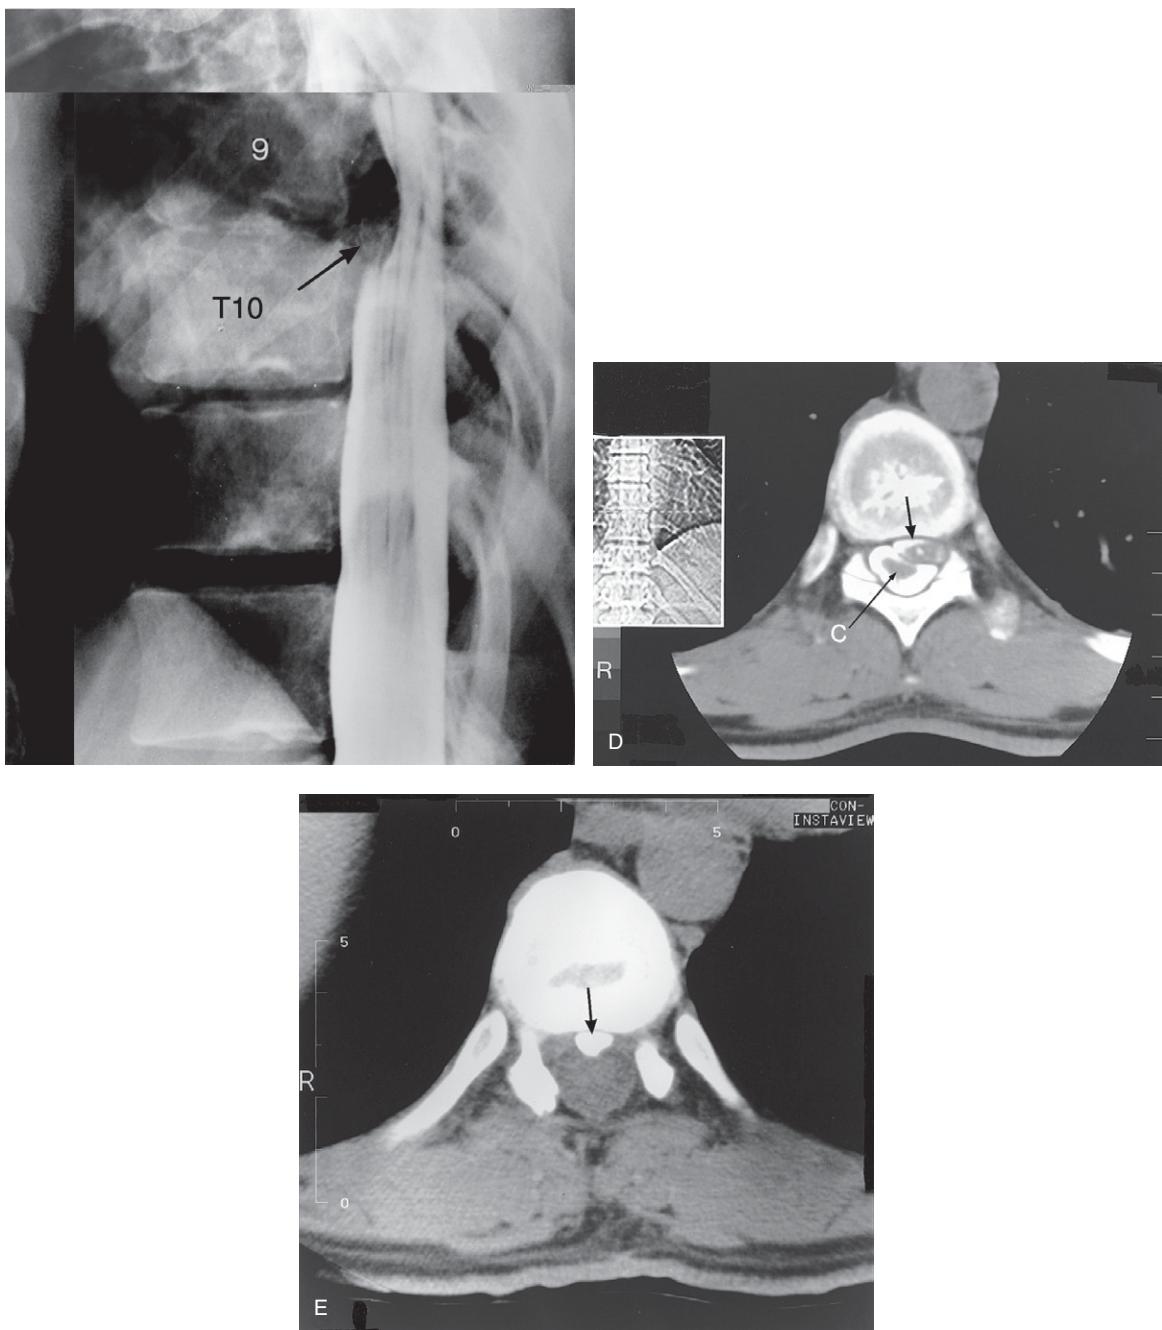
Cont'd (C) A thoracic spine myelogram showing a 'minimal hold-up of the contrast at the T9–10 level' due to an extradural indentation (black arrow). 9 = ninth thoracic vertebra; 10 = tenth thoracic vertebra. (D) A post-contrast thoracic spine CT image showing a central to left sided calcified extradural mass at the T9–10 level (arrow), i.e. a calcified disc protrusion. C = spinal cord within the cerebrospinal fluid. Note that the cord is somewhat displaced. R = right side of patient. (E) A post-surgery thoracic spine CT image showing that there was still 'a prominent piece of ossification centrally and anteriorly in the spinal canal' thought to be causing some degree of cord compression at this level (arrow). R = right of patient.
